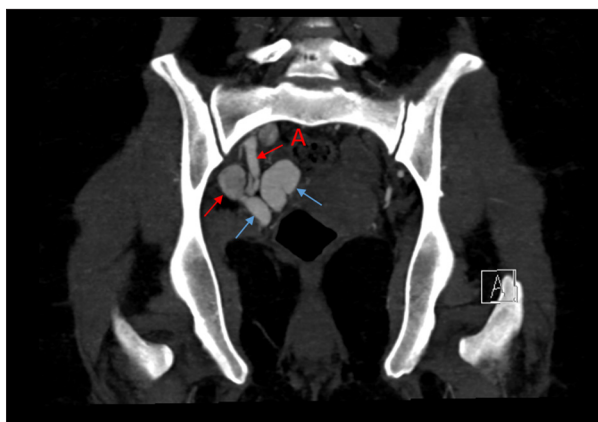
Computed tomography angiogram of the pelvis; coronal view of internal iliac artery (red arrow A) with nidus (red arrow) draining into multiple draining veins (blue arrow).
